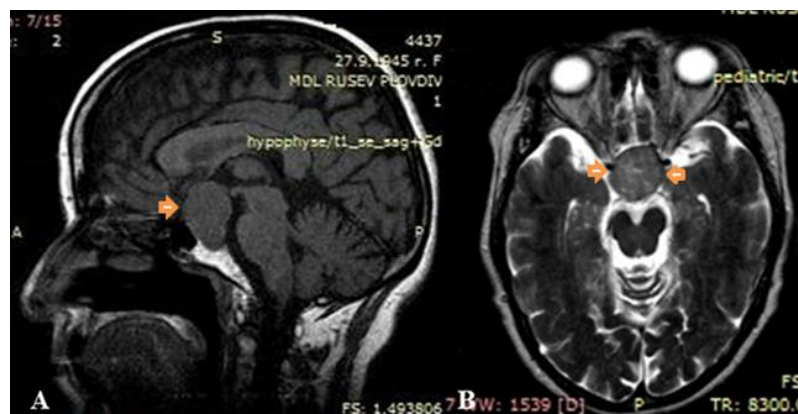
MRI image of giant pituitary adenoma: A/ sagittal image; B/ axial image
